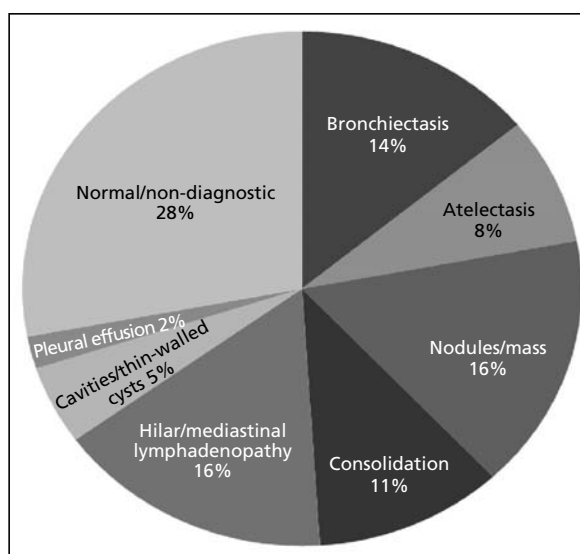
CT findings in patients with chronic cough.
